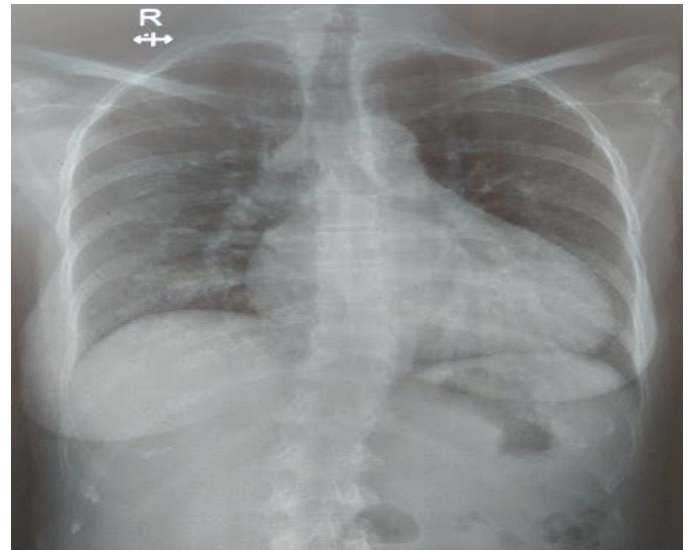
Chest X-Ray PA view: Cardiomegaly
